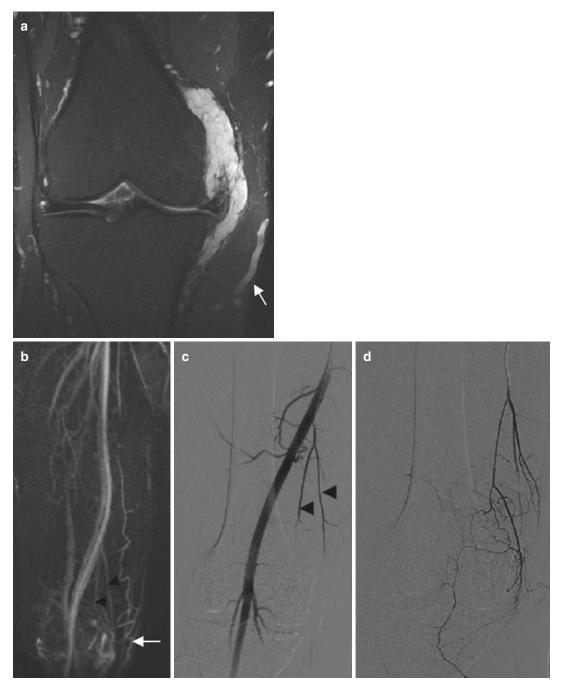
Arteriovenous malformation of the knee in a 30-year-old man. (a) Coronal T2-weighted MR image with fat suppression. (b) Maximum intensity projection (MIP) after 3D contrast-enhanced MR angiography. (c, d) Conventional angiographic images acquired during early arterial phase before the treatment. (a) The lesion is composed of tortuous enlarged feeding arteries located within
